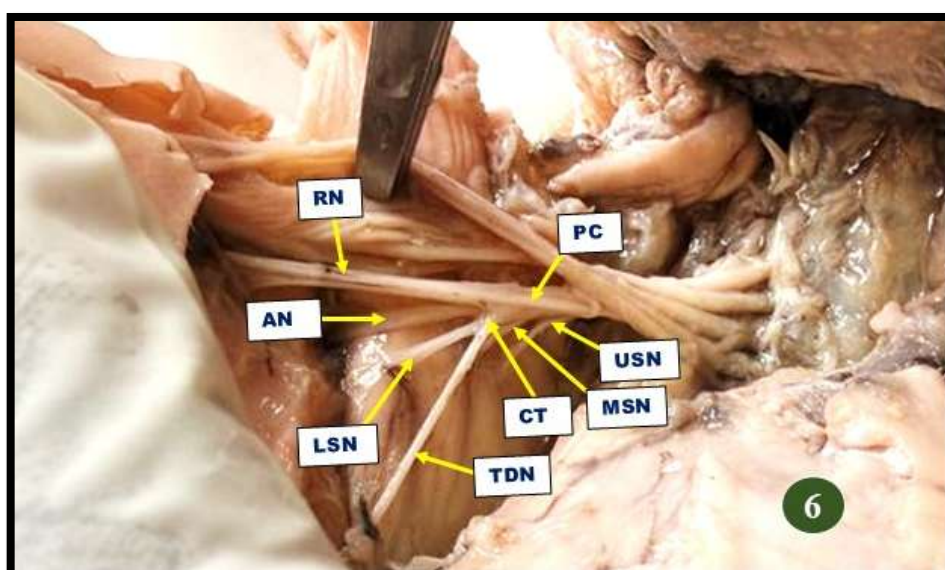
Shows Common trunk (CT) for Thoracodorsal nerve (TDN) and Lower subscapular Nerve (LSN) from Posterior cord of Brachial Plexus
